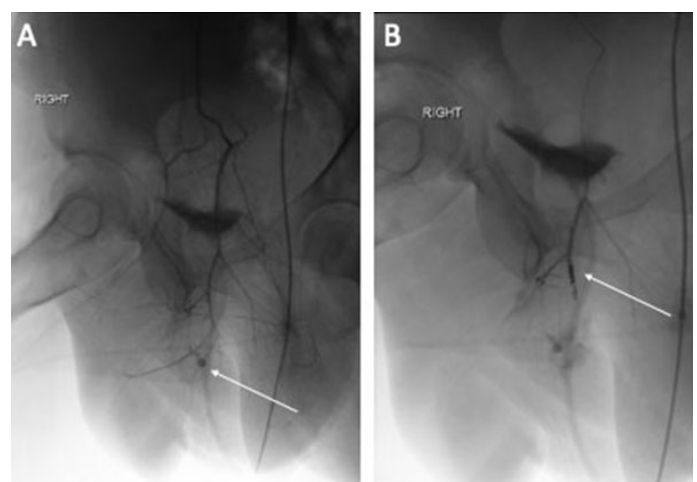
CT angiography. (A) Pseudoaneurysm (arrow) with active bleed from the branches of the right obturator artery. (B) Coil embolization (arrow) of the distal right obturator artery branches that supply the pseudoaneurysm.
